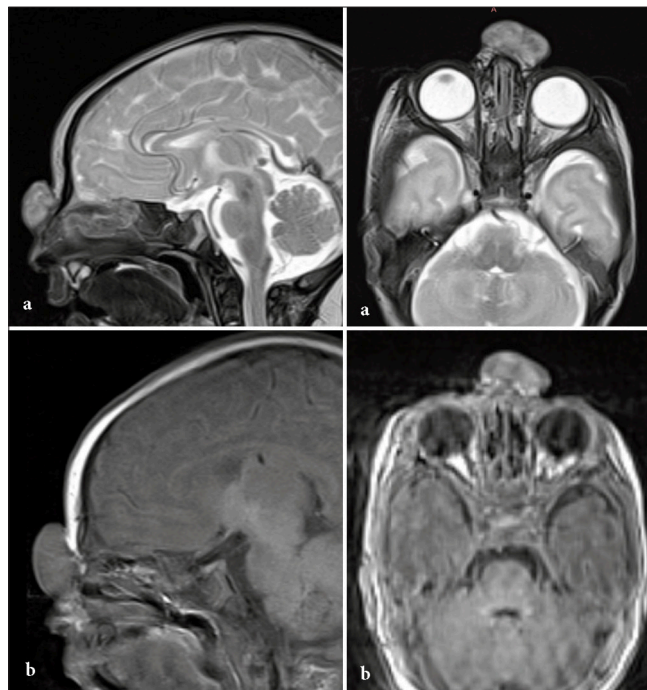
Magnetic resonance imaging showing extranasal lesion. (a) T2 axial and sagittal images showing lesion isointense signal. (b) T1 axial and sagittal images showing lesion isointense signal.
